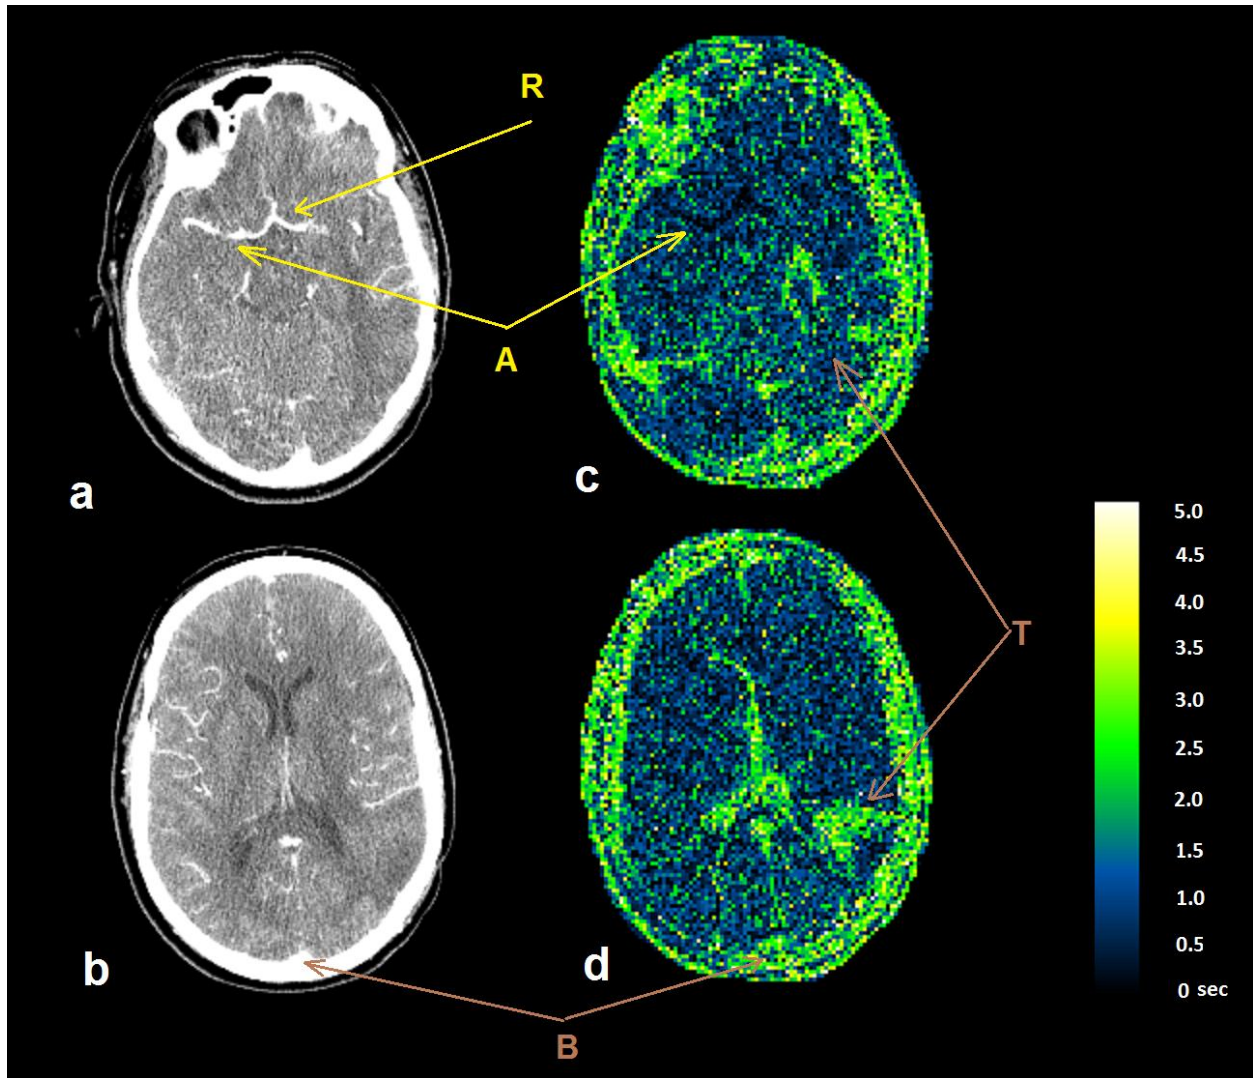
(a),(b) Two sections of post injection CT images and (c),(d) the delay (arrival time) maps (in seconds) created using the parameters found by our method. ‘R’ is the reference point for measuring the global AIF. ‘A’ is the location of one of the main arteries (short delay) and ‘B’ shows the Superior Sagittal Sinus (long delay). ‘T’ shows the location of the tumor.
